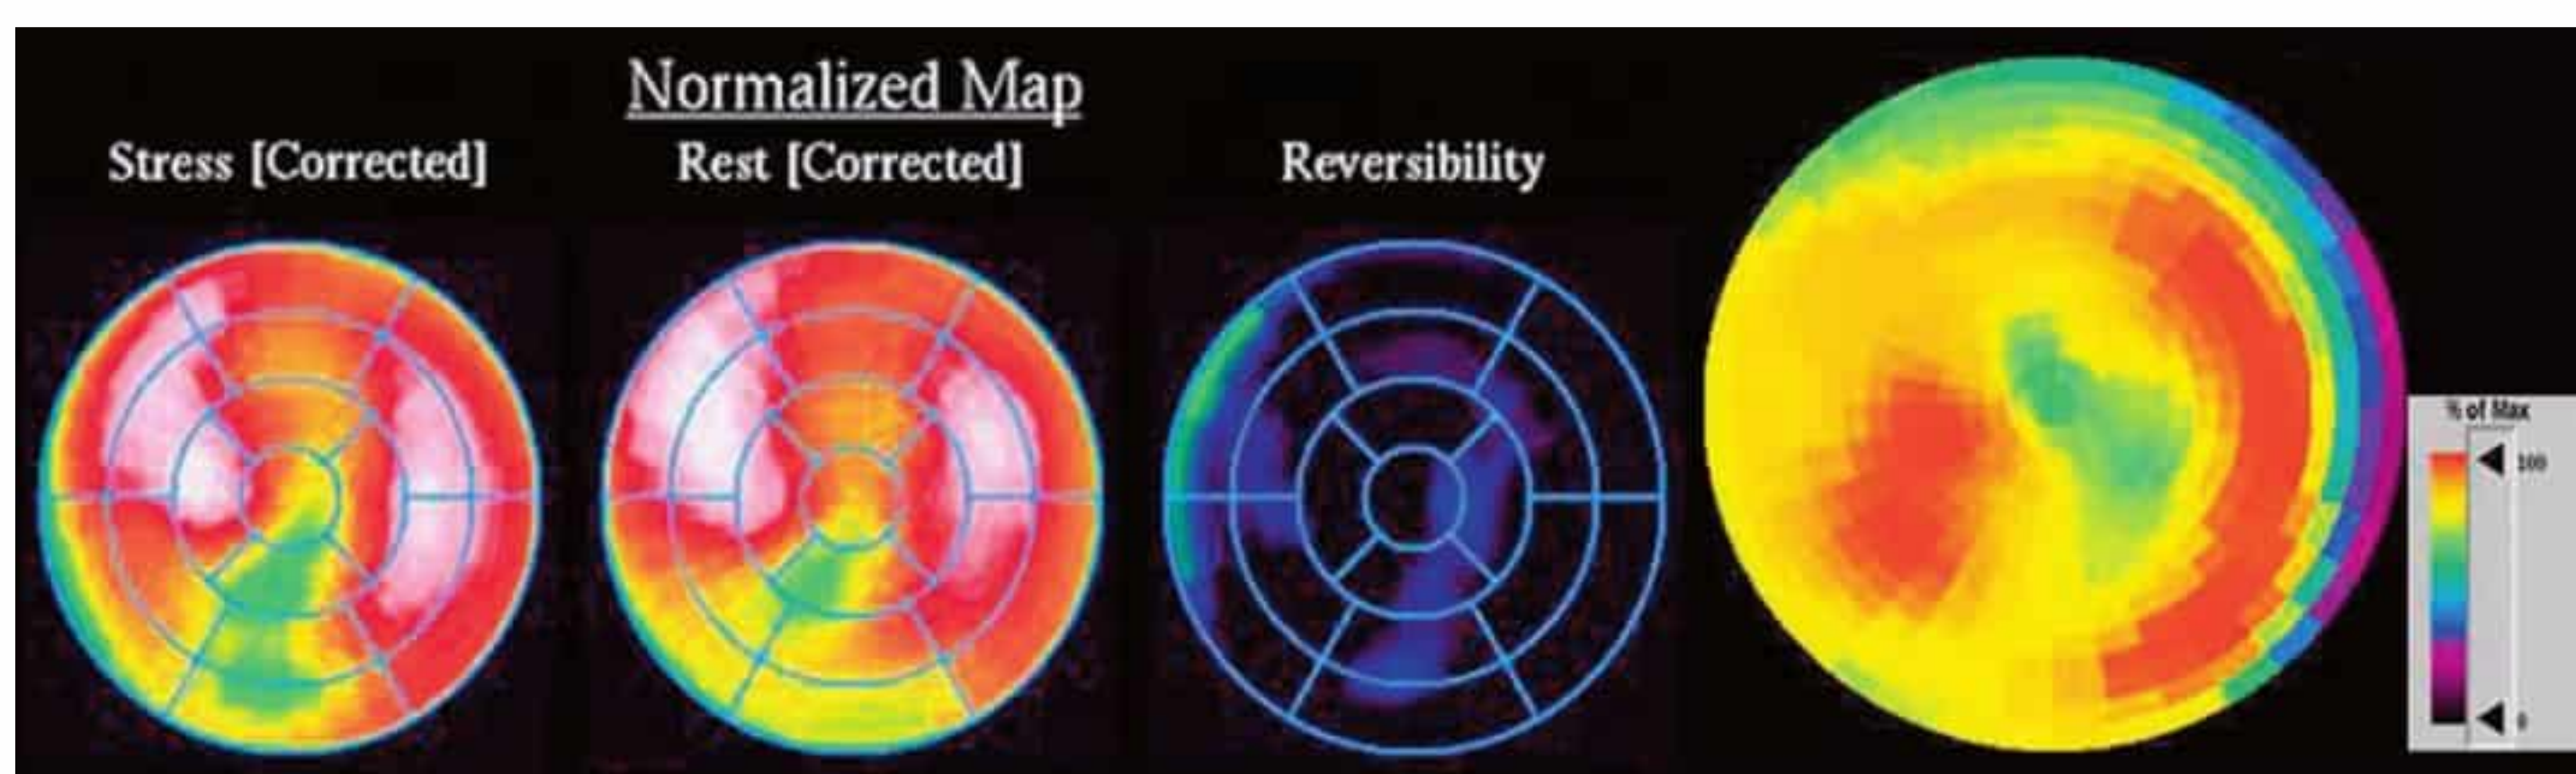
Hibernating myocardium. Scintigraphy shows a fixed, irreversible perfusion defect in portions of the cardiac apex and adjacent posterior wall. [18F]FDG-PET shows normal to slightly increased glucose utilization in this area
